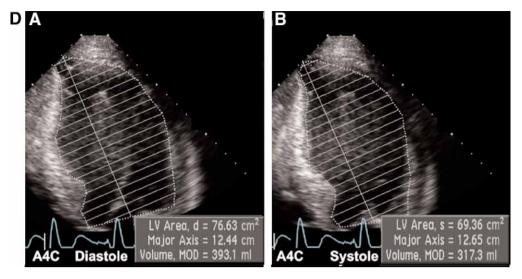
(A) A 72-yr-old man with history of coronary artery disease and heart failure. The left ventricular ejection fraction measured 15%. The apical septal and apical inferior segments were aneurysmal. The entire anterior wall, mid- and distal lateral walls, anterior septal, midposterior segment, midseptal segments, midinferior segment, and basal septal segments were akinetic. The basal lateral and basal inferior segments were hypokinetic. The basal inferior segment contracts and thicken normally. Right ventricular size was not enlarged and right ventricular systolic function was preserved. (B) Computerized record of regional wall motion scores. Computerized record of left ventricular wall motion of patient in A with wall motion score index (WI) of 3.1 (normal = 1) (please see C). (C) Left ventricular segmental nomenclature. Left ventricular segmental nomenclature according to the American Heart Association/American Society of Echocardiography recommendations (see Fig. 10A,B). (D) Left ventricular volumes calculated by the biplane method of discs. The recommended method of quantifying left ventricular ejection fraction employs volumetric calculations using two orthogonal biplanes according to the method of discs, (see Fig. 14). (Please see companion DVD for corresponding video.)
